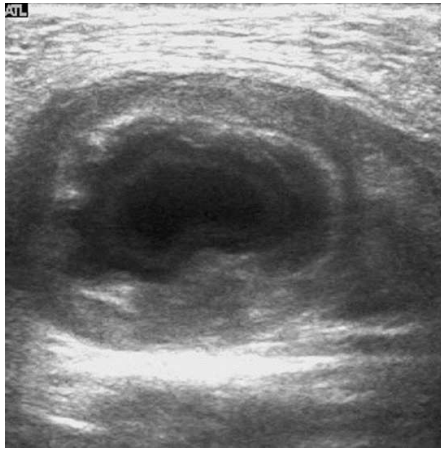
Ultrasound scan of the right inguinal mass revealed a 3.9×2.2 cm laminated mass.
